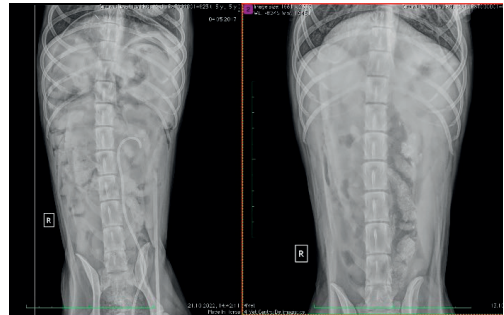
Radiographs taken before (right) and after (left) the surgical procedure
